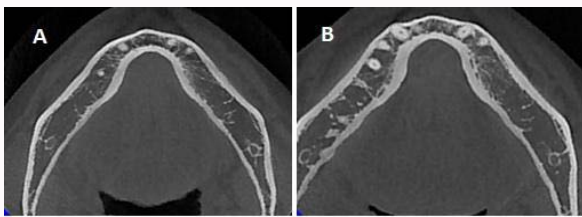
The CBCT image in 2022 (Figure A) reveals the presence of recurrent tumor, characterized by distinct low-density shadow masses (indicated by the green arrow). Prior to surgery in 2024, an enlargement of these low-density shadow masses is observed on the CBCT image (Figure B), as indicated by the red arrow.
